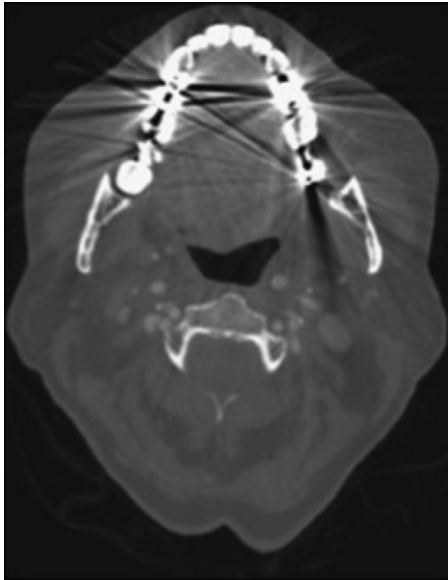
Streak artifact in CT axial slice image.
